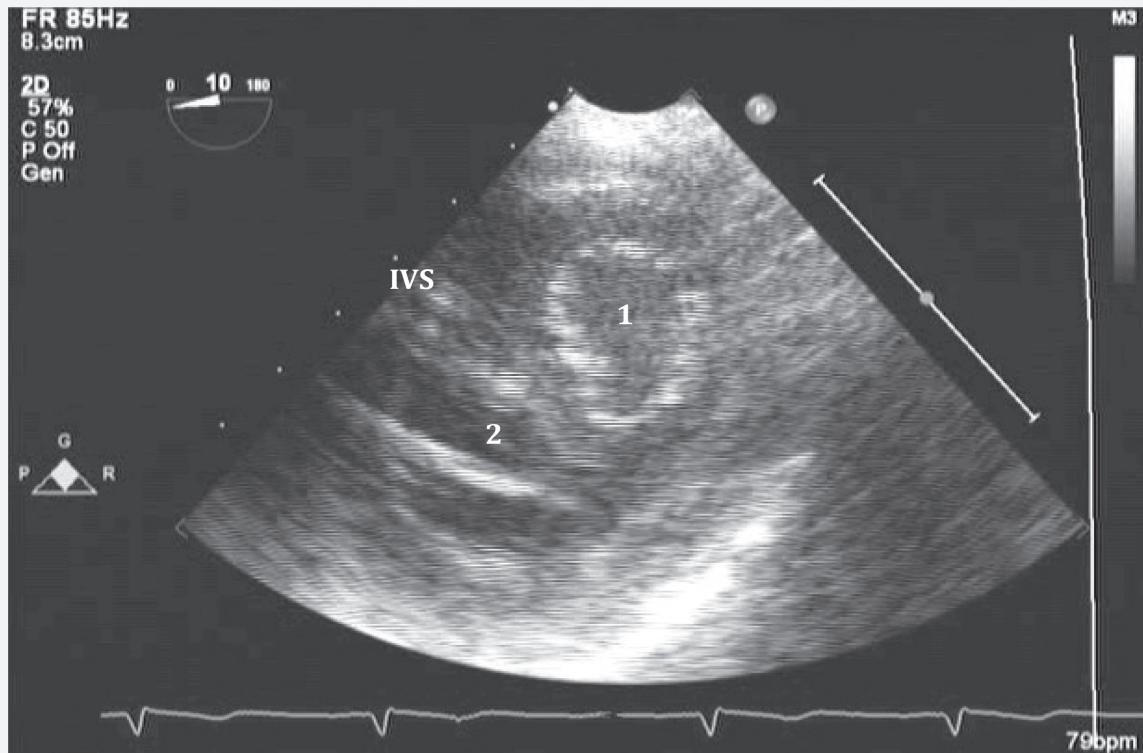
Transesophageal 2D echocardiography deep transgastric short-axis view of the mitral valve demonstrating two mitral valve orifices—one located posteriorly (1) and the other more anteriorly (2). Abbreviations: 2D, two-dimensional; IVS, interventricular septum.
